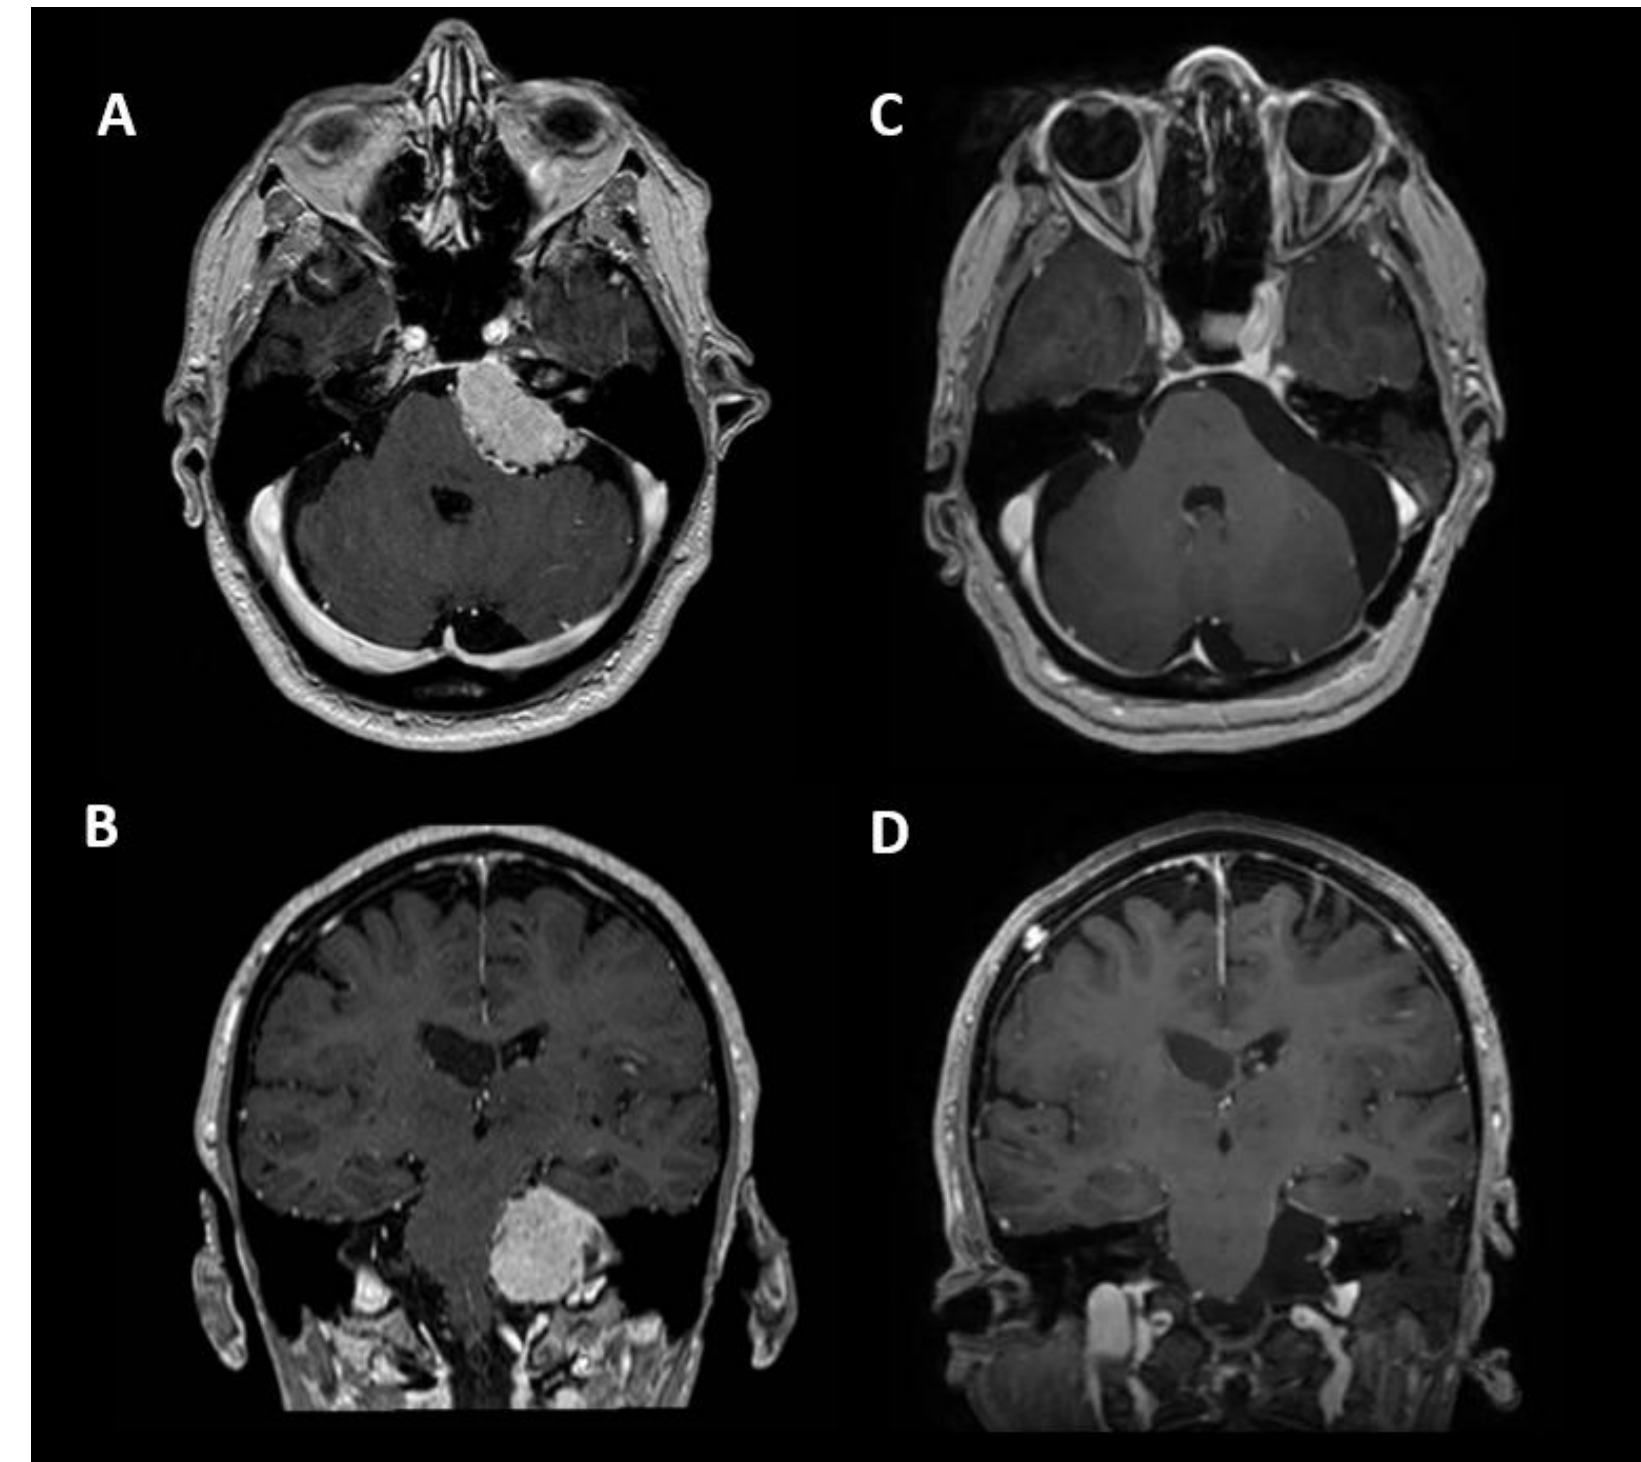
Preoperative (A-B) and postoperative (C-D) MRI with gadolinium demonstrating GTR of petroclival meningioma through a retrosigmoid approach.
